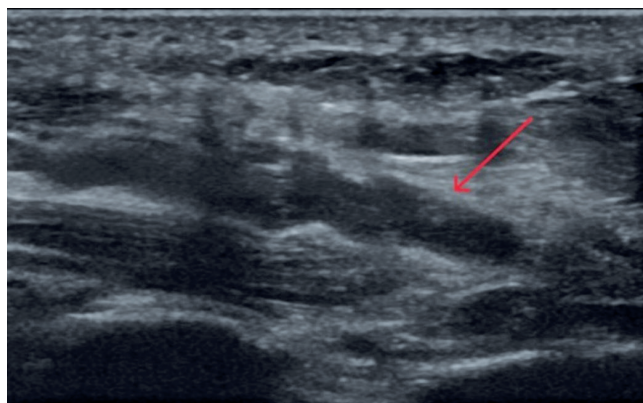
Longitudinal gray-scale (B-mode) ultrasonography of the medial plantar vein demonstrating plantar vein thrombosis. A hyperechoic intraluminal structure representing thrombus (red arrow) is seen along the course of the vein, which shows increased caliber. Surrounding soft tissue echogenicity is also noted, consistent with perivascular edema.
